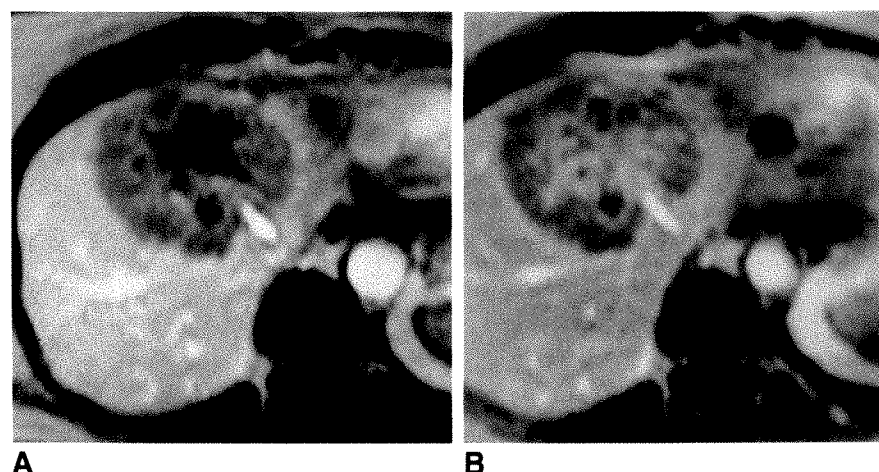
Dynamic gadopentetate dimeglumine-enhanced MR images (GRE 100/5, 80°) of adenocarcinoma metastasis at 1.5 T. Lesion shows inhomogeneous enhancement on immediate (30 sec) image (A) and remains hypointense relative to surrounding liver parenchyma at 5 min (B). Thus hypovascular metastases show limited enhancement with contrast agent.
